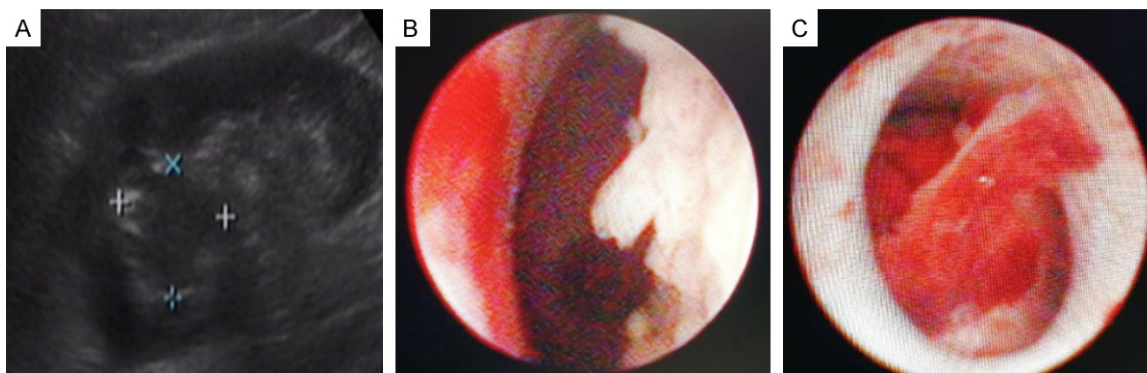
Abdominal ultrasound and cystoscopic examination of the right kidney. A. The abdominal ultrasound showed an unclear, hypoechoic solid mass (2.7 cm in diameter) located in the pelvic portion of the upper pole of the right kidney. B and C. The cystoscopic examination showed a cauliflower-like mass in the renal pelvis.
